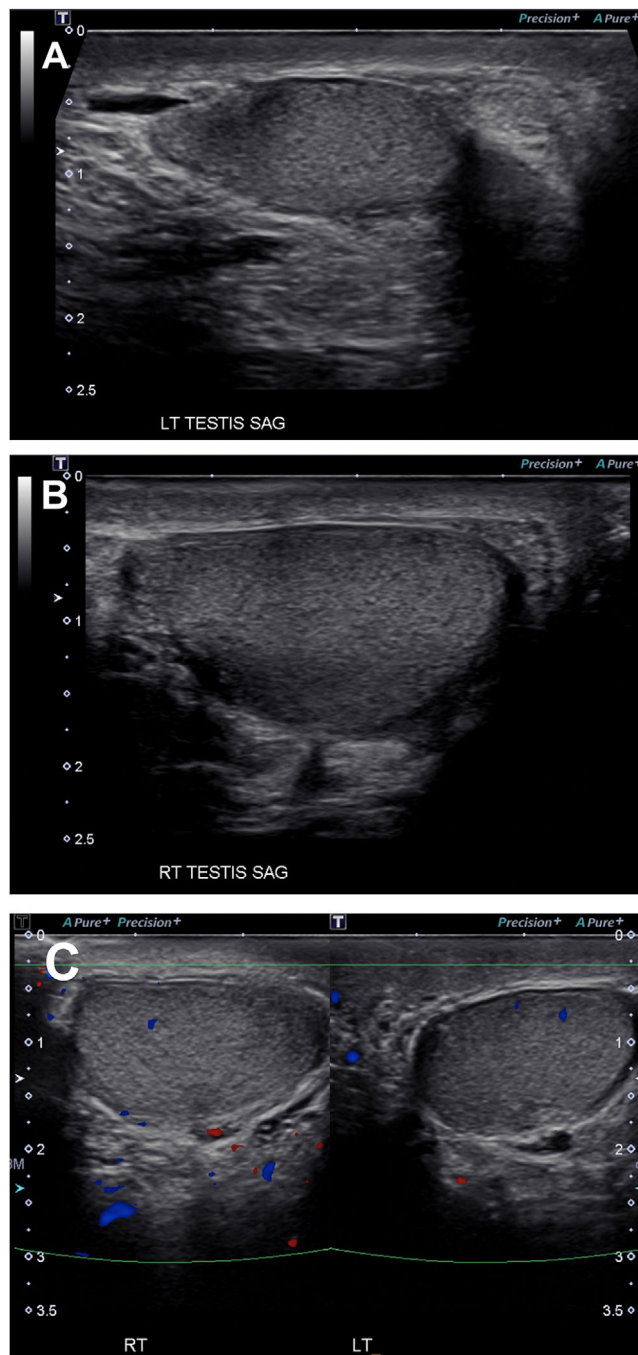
A. Left testicle noted to be atrophic and have a homogenous echotexture with a size of $2.9 \times 1.2 \times 1.9$ cm. B. Right testicle noted to be atrophic and have a homogenous echotexture with a size of $2.7 \times 2.7 \times 1.5$ cm. C. Color doppler ultrasound of both testicles
